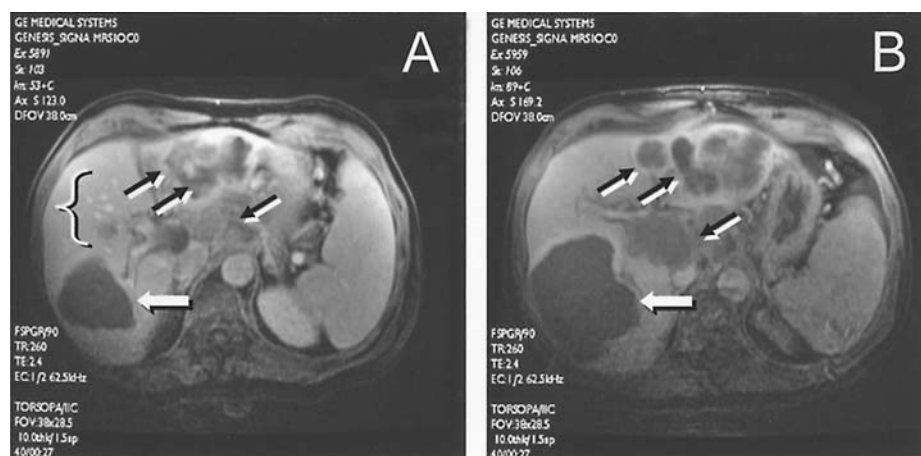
Effects of Rexin G infusions on the number and quality of hepatic metastatic lesions observed in a pancreatic cancer patient exhibiting a massive tumor burden (Patient C1). Abdominal MRI obtained (A) before treatment and (B) after treatment with calculated (Calculus of Parity) dose-dense infusions of Rexin-G. Note the complete eradication of numerous small dense tumor nodules in the upper left quadrant of the image (bracketed), as well as cystic conversion of established liver nodules (black arrows). Subsequent aspiration of the enlarged liver cyst (white arrow) followed by cytological analysis confirmed the complete absence of cancer cells in the aspirates following the treatment.
